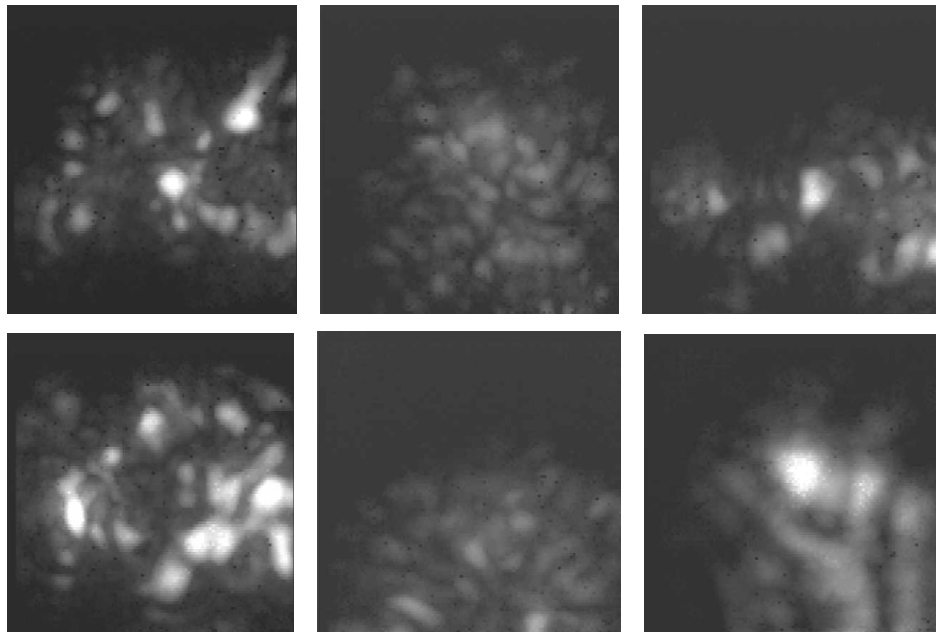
C-scan breast images of human breasts acquired by the ultrasound mammography prototype using I-400 sensor array operated at 4MHz.
